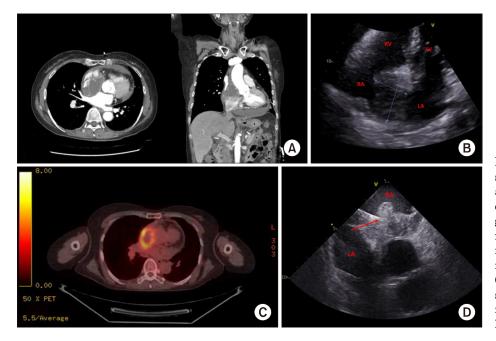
(A) Chest computed tomography shows a 6.8-cm-sized mass in the right atrium. Narrowing of the superior vena cava (SVC). (B) Transthoracic echocardiography (TTE) shows a mass inside the right atrium. (C) Positron emission tomography is performed to detect the primary origin of the right atrial (RA) mass. (D) Intracardiac echocardiography (ICE) shows a right atrial (RA) mass. The biopsy forceps were positioned within the mass located in the right atrium (arrow).
